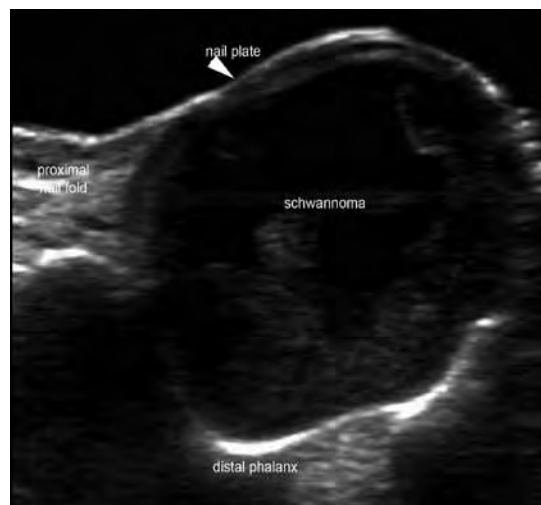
Ultrasonography view of a big toe schwannoma. A subungual mass with a hypoechoic rim (solid) (gray) and an anechoic center (cystic) (black). © X. Wortsman
